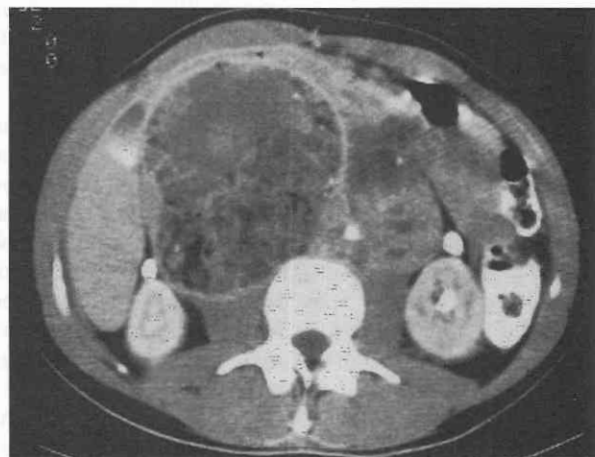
Metastatic testicular teratocarcinoma. Nondynamically enhanced CT scan shows retroperitoneal lymph node metastases. Huge nodal masses with areas of fat, fluid, and calcification are characteristic.
